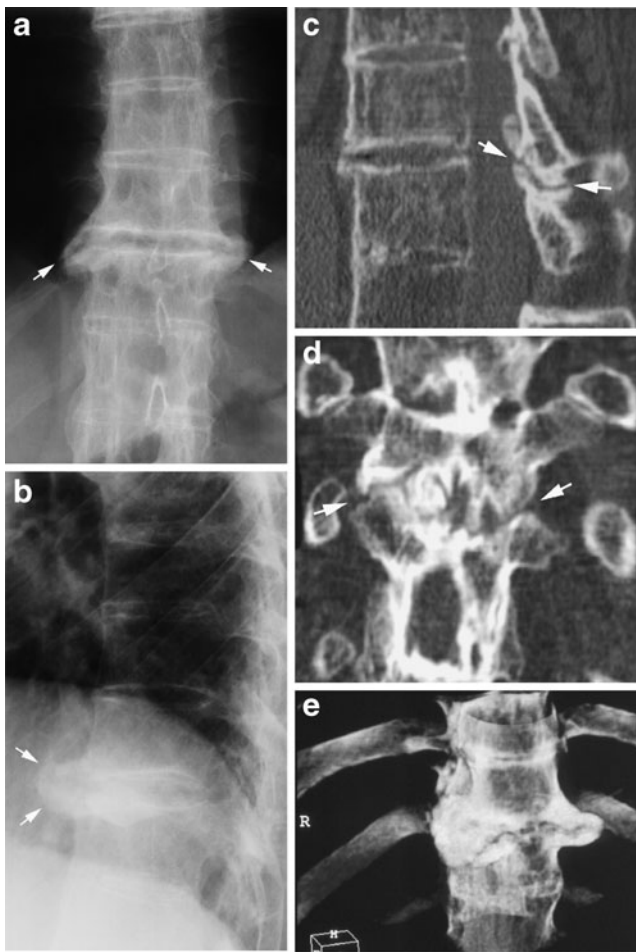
Pseudo-arthritis-like changes in AS. (a) AP and (b) lateral radiograph showing vertebral fusion except at iv Th10/11. There is surrounding osteophyte formation at this iv space (arrows). Supplementary CT, (c) sagittal and (d) coronal 2D reconstruction, demonstrates lack of fusion of the vertebral bodies and apophyseal joints at this level (arrows). (e) 3D reconstruction clearly demonstrates the exuberant surrounding reactive osteophytes
